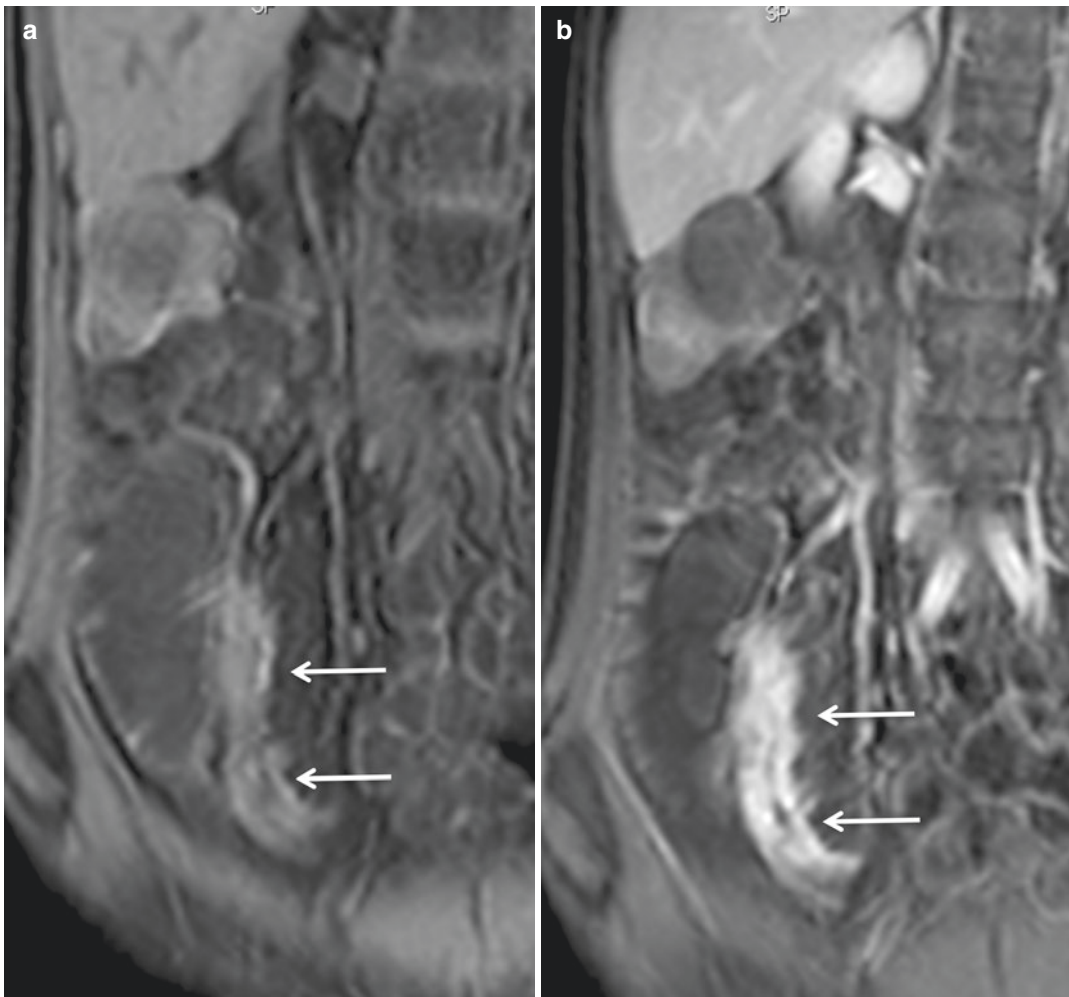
Coronal fat-suppressed 2D GE T1-weighted image obtained before (a) and after i.v. contrast medium administration (b) in a patient with active Crohn's disease of terminal ileum (arrows)
